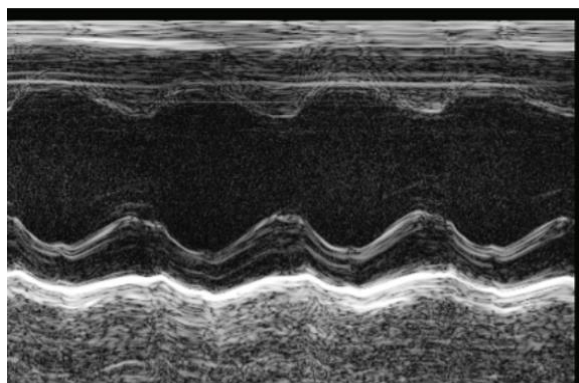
Representative B-mode echocardiographic images in MR hearts before and at 6 weeks after rapamycin pumps insertion
